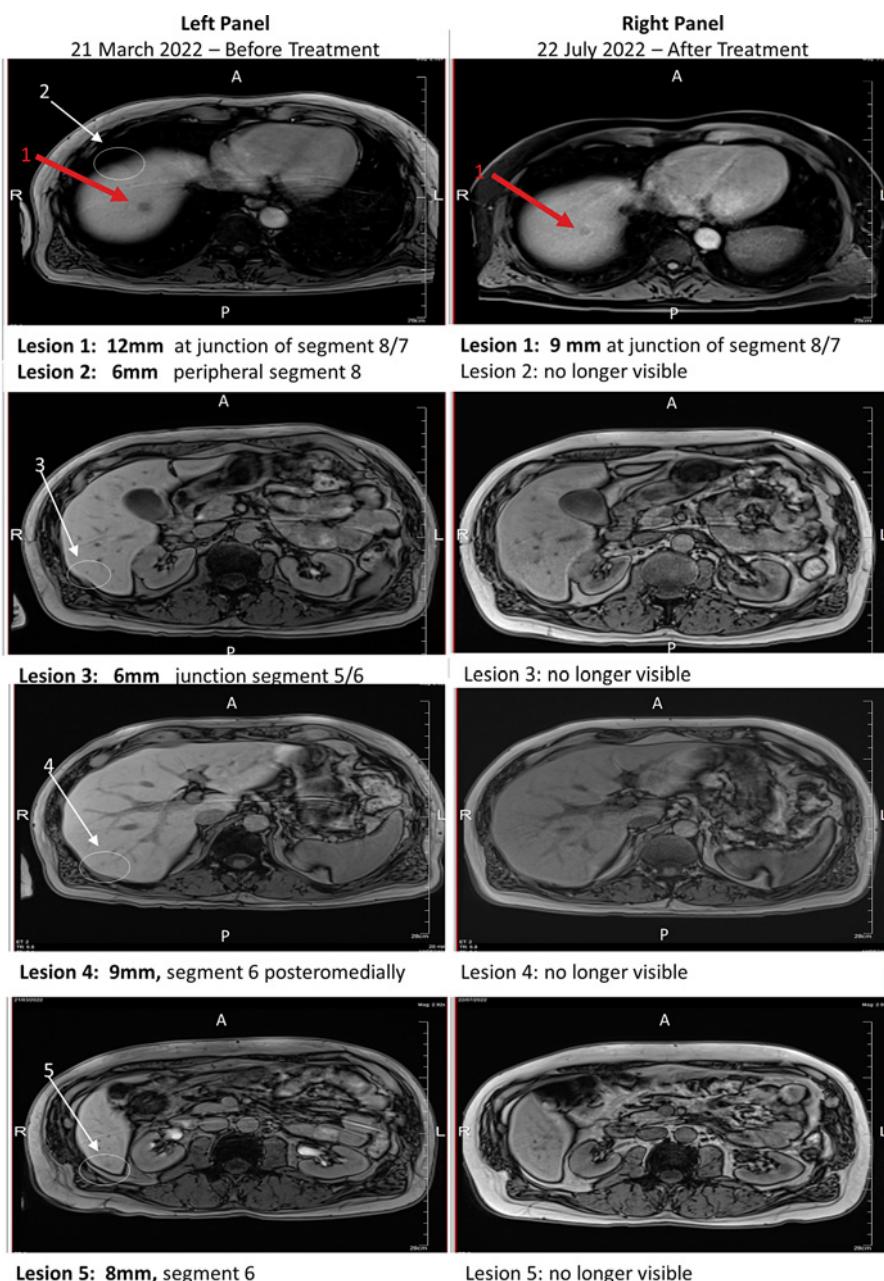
MRI images of the liver before and after treatment. Left panel (before treatment): MRI images of the patient's liver on March 21, 2022. Five lesions were detected before treatment, including the main lesion 1, 12 mm in size (red arrow) and 4 smaller lesions 2–5 (white arrows). Right panel (after treatment): MRI images on July 22, 2022. Lesion 1 reduced in size 9 mm (red arrow) and previous 4 smaller lesions were no longer visible. A, anterior (front of patient); P, posterior (back of patient); R, right side of patient; L, left side of patient.
